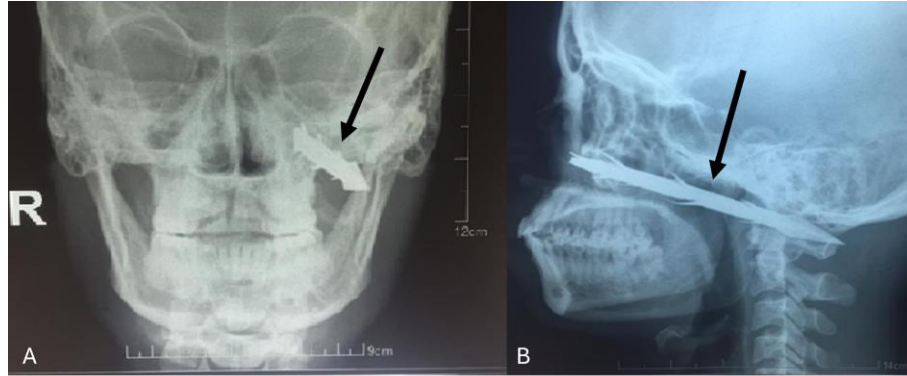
Plain radiographs, frontal (A) and anteroposterior (B) view. Arrow: the tract of the arrow.
